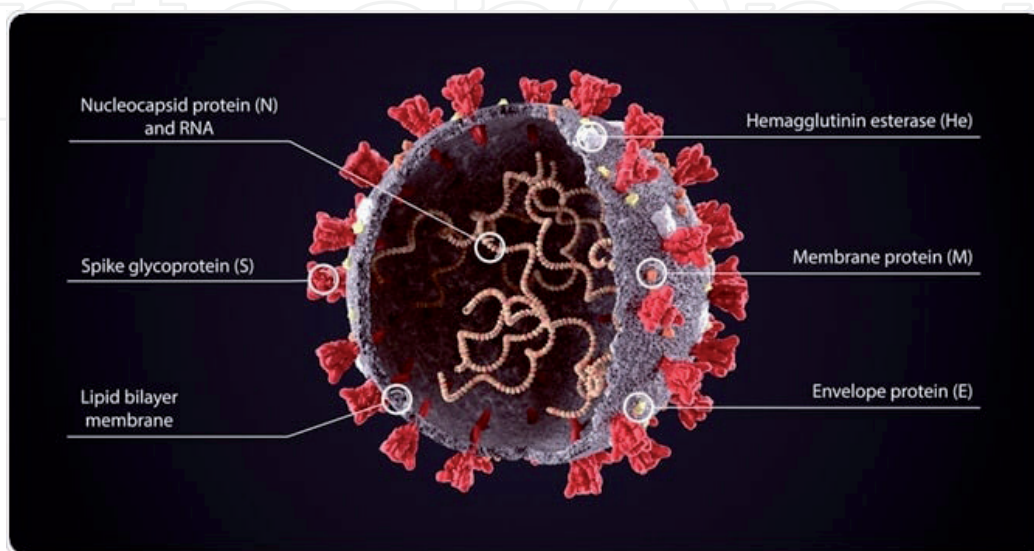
Structural proteins. (reprinted from: *The week: X-rays size up coronavirus protein structure at room temperature* [9]).
